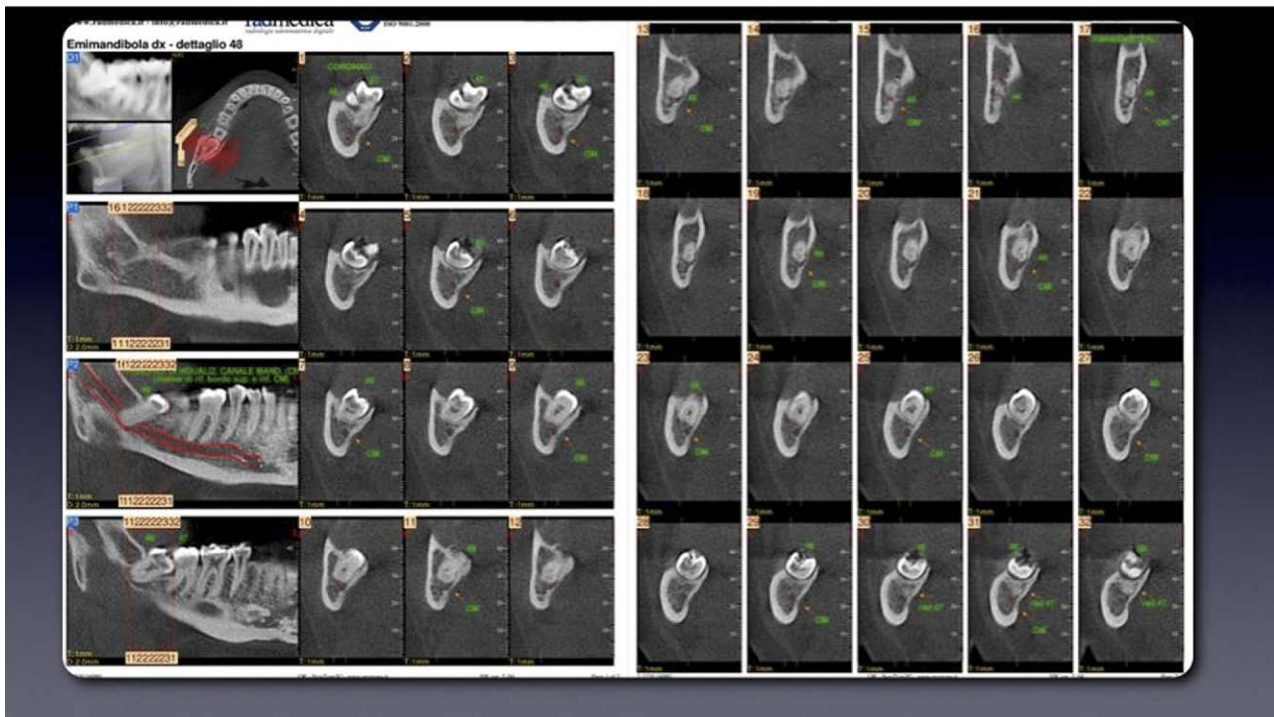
Computed tomography scan of the right third molar area. The close proximity of the roots of the right mandibular third molar and the inferior alveolar nerve bundle is clearly visible. Tooth extraction would result in a high risk of nerve injury.
